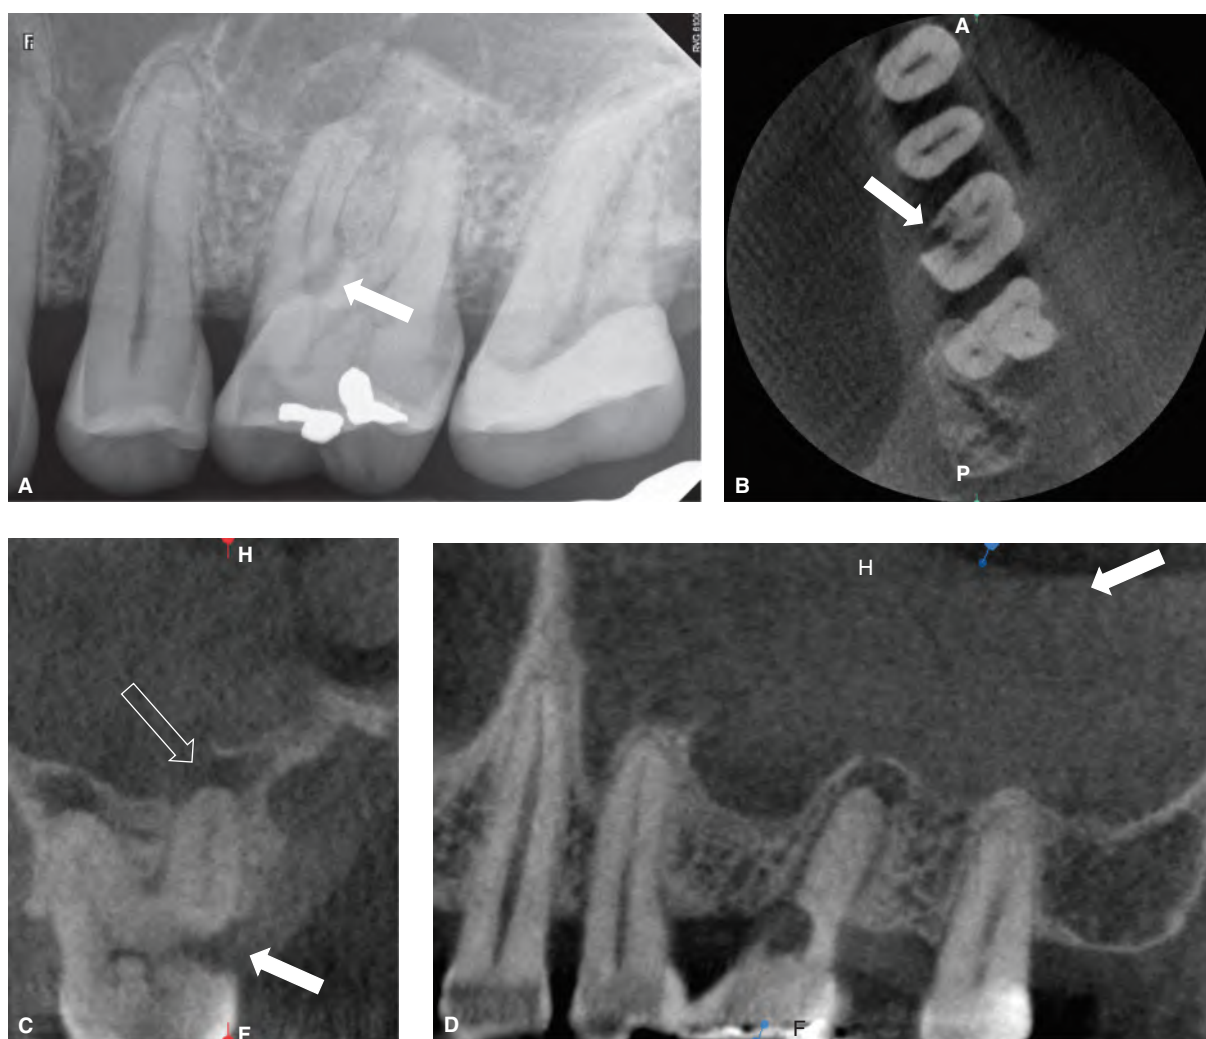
9 CBCT has been shown to be more accurate than periapical radiography in the detection of invasive cervical resorption. A. Periapical radiograph shows the maxillary left first molar with an irregular region of medium attenuation at the junction of the mesiobuccal and palatal roots (solid arrow), rarefying osteitis at the periapices of the of the mesiobuccal, distobuccal, and palatal roots and lifting the sinus floor. B. Axial reformation shows the true extent of an irregular region of low attenuation (solid arrow), a feature consistent with invasive cervical resorption. C. Cross-sectional reformation shows a wedge-shaped region of low attenuation of the palatal root (solid arrow), large pulp stone, rarefying osteitis of the mesiobuccal and palatal roots with erosion of the sinus floor (outline arrow) and mucositis of the portion of the sinus imaged. D. Panoramic reformation of the palatal root with osteoperiostitis and mucositis (solid arrow).
